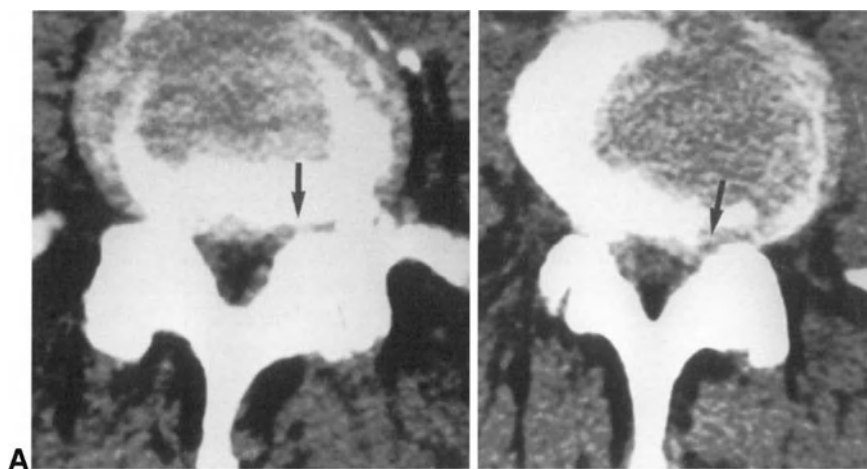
Disc herniation and nerve-root canal stenosis. CT scans showing bilateral stenosis of the nerve-root canal (A), more severe on the left side (arrow), and concomitant posterolateral and intraforaminal disc herniation (B) on the left (arrow). Laminotomy and discectomy were carried out on the left.
